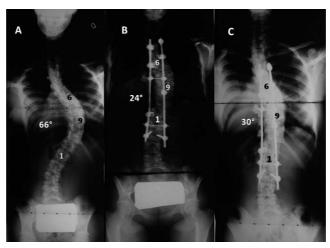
Coronal correction in a patient with a Lenke type I curve. Both the angles corresponding to the curves according to Cobb and the limiting vertebrae are shown (sixth thoracic vertebra and first lumbar vertebra), and the apex (ninth thoracic vertebra). A) Preoperative x-ray. B) Postoperative x-ray. C) At 3 years. An immediate 63% correction was obtained that desecended to 54% after the loss of a 6° correction and its subsequent stabilization. The bending test yielded a correction of 48° (27% lateral correction). There were no cases of nonunion.
